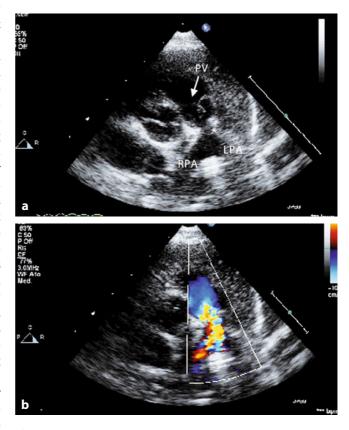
Echocardiogram picture of pulmonary artery banding. a Pulmonary valve (PV); Pulmonary banding (*asterisk*). *LPA* left pulmonary artery, *RPA* right pulmonary artery. b Color flow picture showing flow acceleration across the banding
